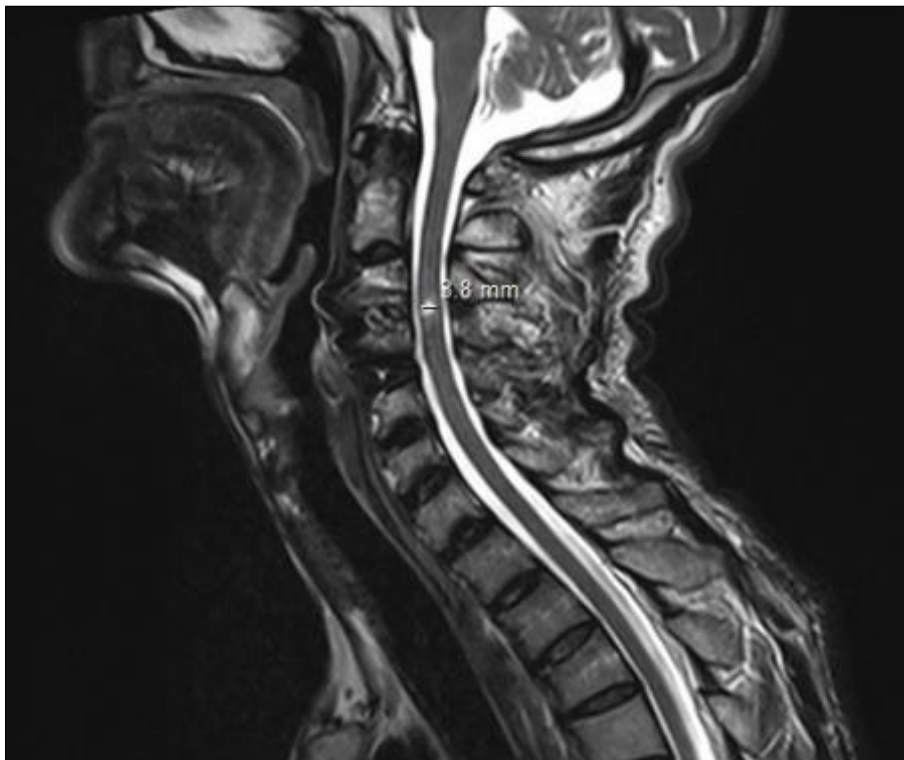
Spinal cord MRI showing a centromedullary hyperintensity opposite C3 to C4 measuring 4x3.8mm in relation to spinal cord injury, associated with an aspect of degenerative cervical myelopathy .
